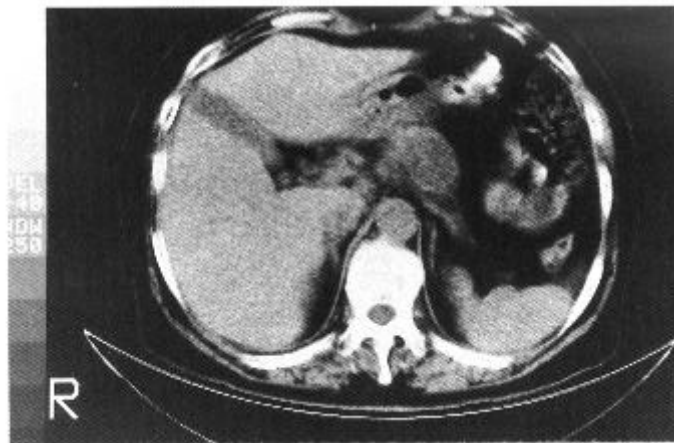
A 67-year-old female with pancreatic cyst (Case 9 in Table 2). (A) X-CT: The pancreatic cyst of the body ~ tail can be recognized as low density area. (B): PET images of the left is more cranial than the right. Upper line is PET images using ^{11}C -Met. The head of the pancreas can be shown. Lower line is PET images using ^{18}F FDG. The pancreatic cyst can not be visualized as hot image.
